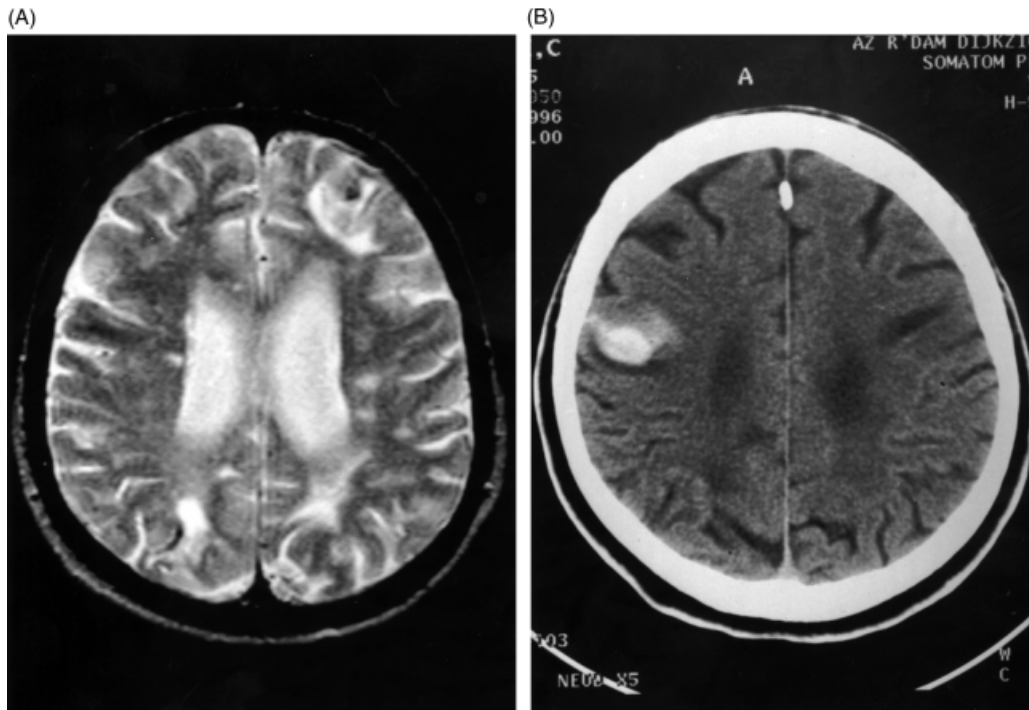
(A) MRI scan typical of patients with dementia carrying the APP692 mutation. There are cortical and central atrophy and numerous white matter lesions, which are most prominent adjacent to old haemorrhages in the frontal and occipital cortices. (B) Circumscribed haemorrhage in the right parietal cortex and global cortical atrophy.
